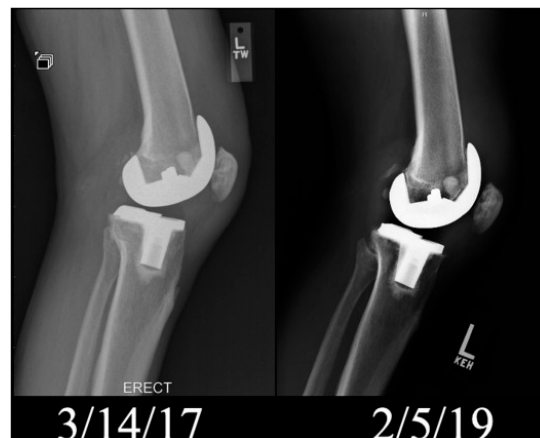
Radiograph (lateral view) of left knee post-op and after 2-years follow-up. Reproduced from [127] with the permission from Elsevier™.
